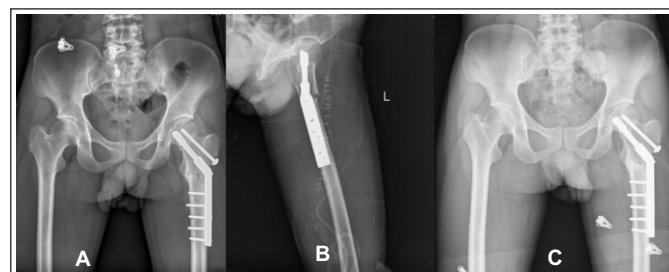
A. Showing immediate post op pelvis with femur X-ray B. Immediate post op left femur lateral view C. Follow up X-ray of pelvis at 6 months with complete union at fracture and osteotomy site.
